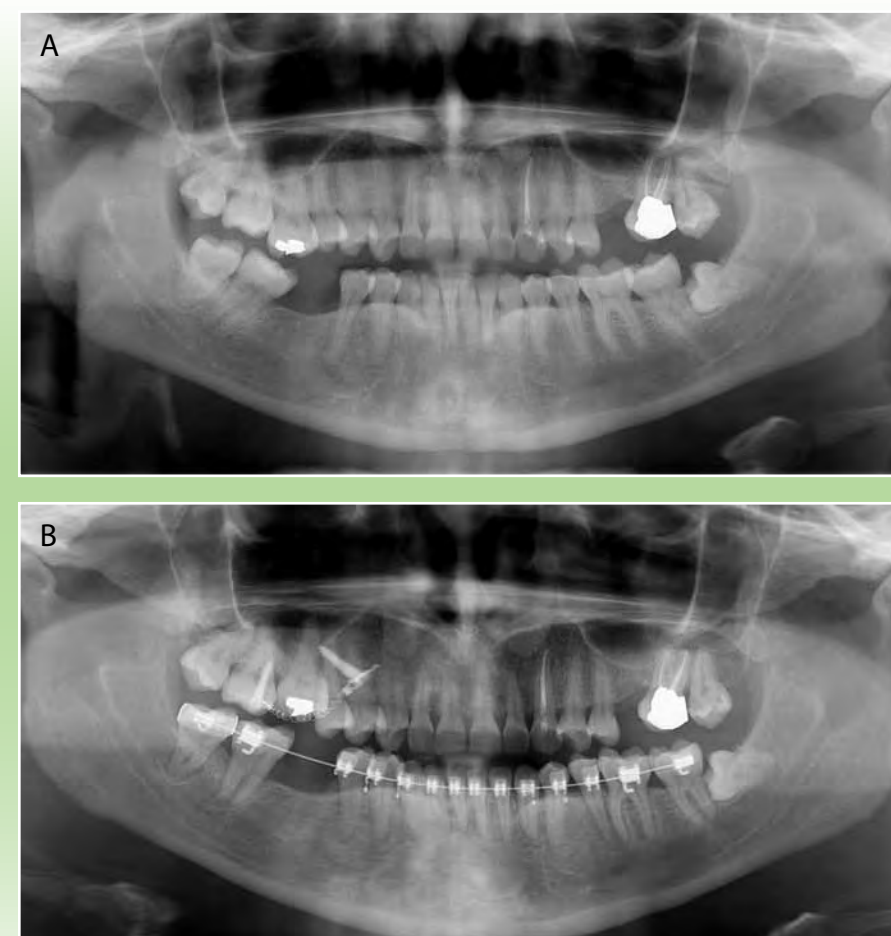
A. Pretreatment panoramic radiograph of patient with a supraerupted maxillary first molar as a result of early loss of the mandibular first molar. B. Postintrinsic panoramic radiograph taken before removal of the temporary anchorage device, showing that 4.4 millimeters of molar intrusion was achieved in less than six months without the need for a fixed appliance. The maxillary molar was intruded within the maxillary sinus without radiographically detectable root resorption. A removable retainer was made to allow the molar to settle into proper occlusion.
